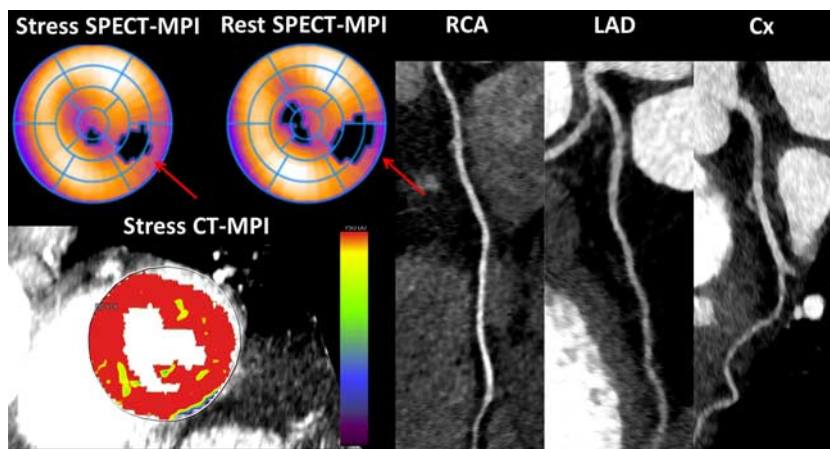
Example of discordant findings between CT-MPI and SPECT-MPI. A 68-year-old woman presenting with chest pain. The attenuation-corrected SPECT images show a fixed defect of 10% (red arrows) in the lateral wall supplied by the Cx territory with the suspicion of being an artifact in both rest and stress SPECT-MPI. This defect is not seen on the CT-MPI images and the CCTA images show no calcifications and no stenoses in the RCA, LAD, and Cx.
